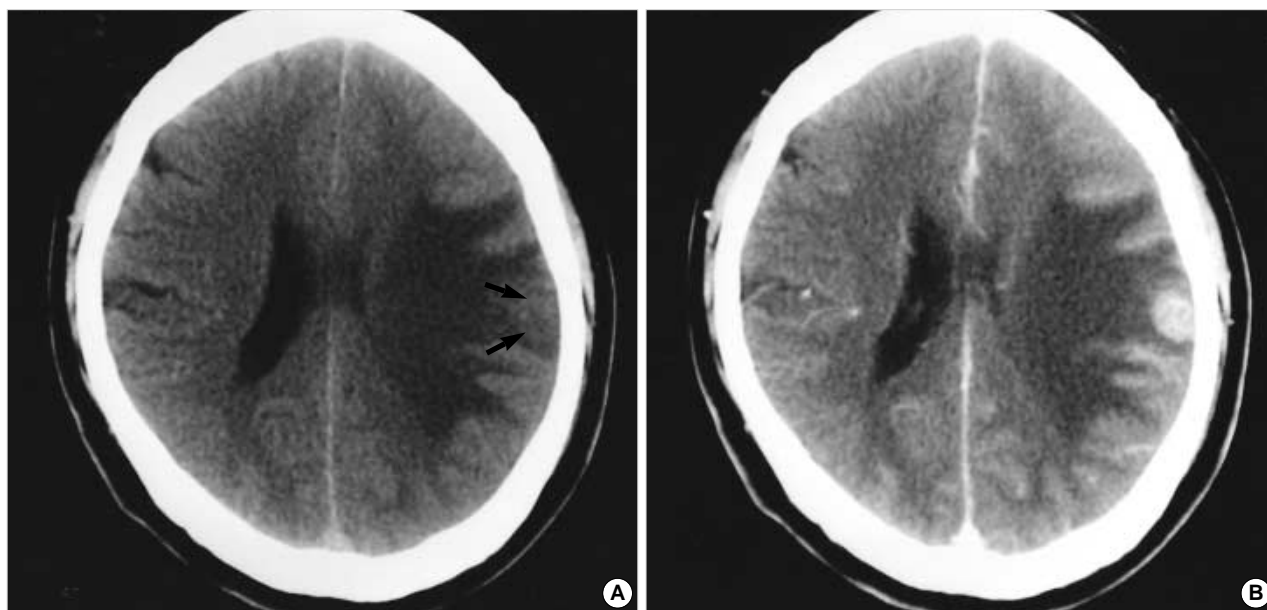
(A) Pre-contrast computed tomography (CT) showing an ill-defined isodense mass (arrows), with severe surrounding edema in the left parietal cortex. (B) Strong homogeneous enhancement of the mass as seen in postcontrast CT.
